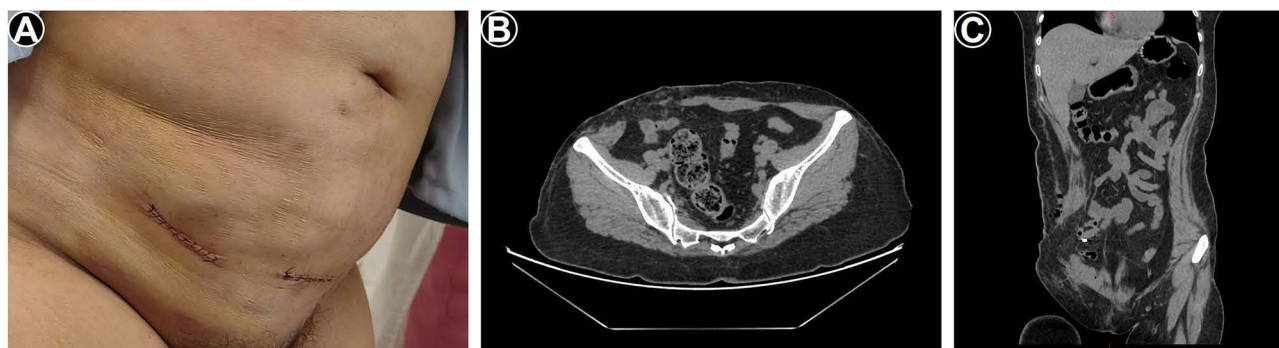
Preoperative symptoms and imaging examination of the patient. (A) The next day after the second surgery, the patient presented with a protruding mass outside the skin of the right lower abdomen. (B) Abdominal wall defect on cross-sectional CT. (C) Abdominal wall defect on coronal CT.
